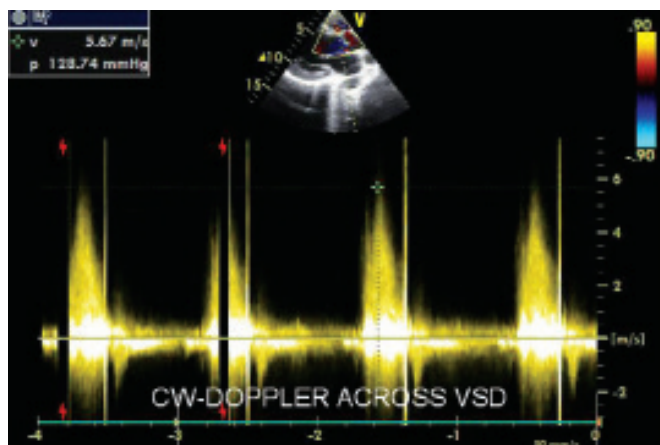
Continuous wave Doppler to measure the pressure gradient across VSD restricted by prolapsed of RCC
